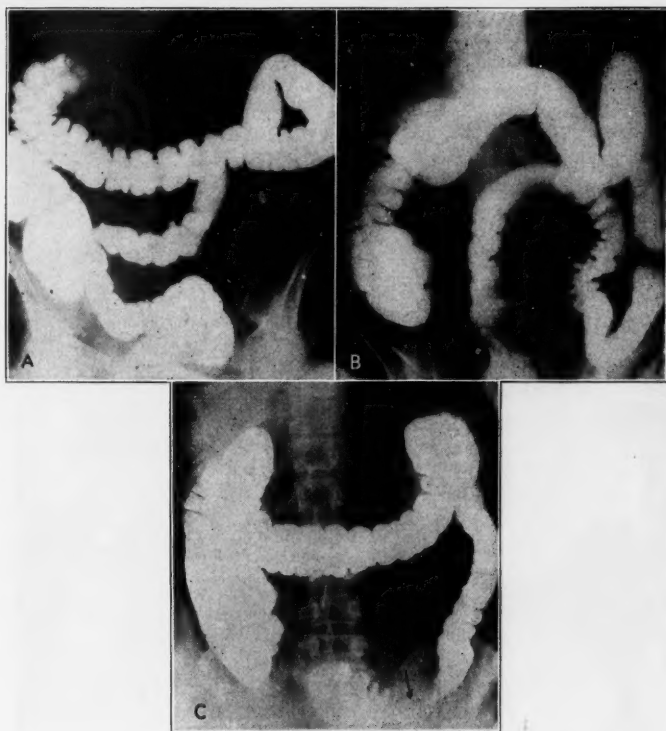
(A) Roentgenogram of sigmoid extending to right lower quadrant. Note several small diverticula in the sigmoid. (B) Diverticulosis of the sigmoid. Note the long loop of sigmoid with evidence of pressure from an extrinsic mass. (C) Roentgenogram showing almost complete obstruction in the sigmoid due to a large inflammatory mass in the area designated by the arrow. The presence of several small diverticula proximal to the lesion is evidence in favor of a non-malignant tumor.
